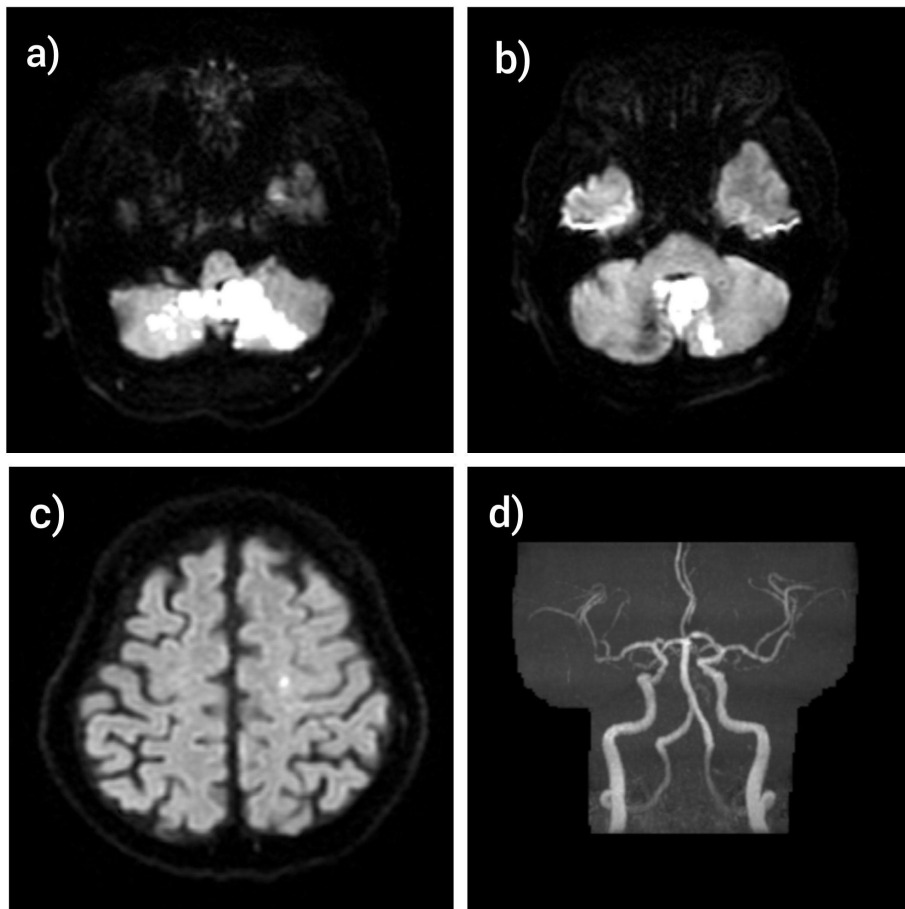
Magnetic Resonance Imaging (MRI) scan of the brain showed a) Bilateral inferior cerebellar hemispheres infarcts with lack of involvement of the dorsomedial surface of the brainstem b) Cerebellar vermis infarct. c) Tiny acute infarct in the left centrum semiovale. d) No large vessel occlusion detected on Magnetic Resonance Angiography (MRA)
